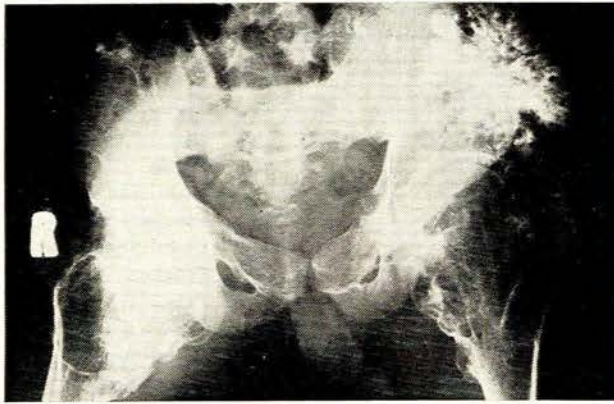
Case 3. Radiographic appearance of a tumour which had increased noticeably in size over 2 years.
